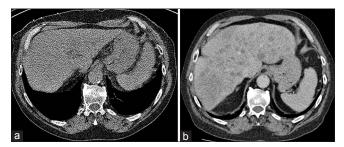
Selected axial computed tomography images from (a) low-dose attenuation correction CT acquired during myocardial perfusion scintigraphy (acquired in prone position) and (b) staging computed tomography performed following lung cancer diagnosis 14 months later. Within the limits of the lower dose scan, no hepatic lesions are seen at the time of myocardial perfusion scintigraphy compared with multiple metastatic lesions on staging computed tomography
